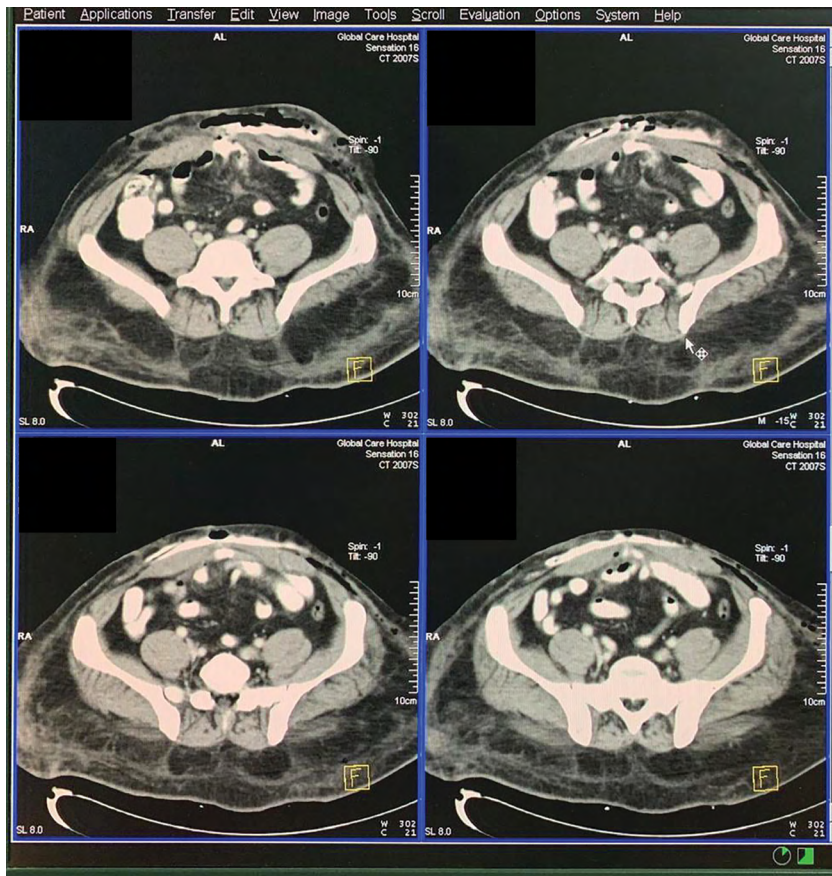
A CT scan of the abdomen showing the leakage of the dye at the site of the perforation.
